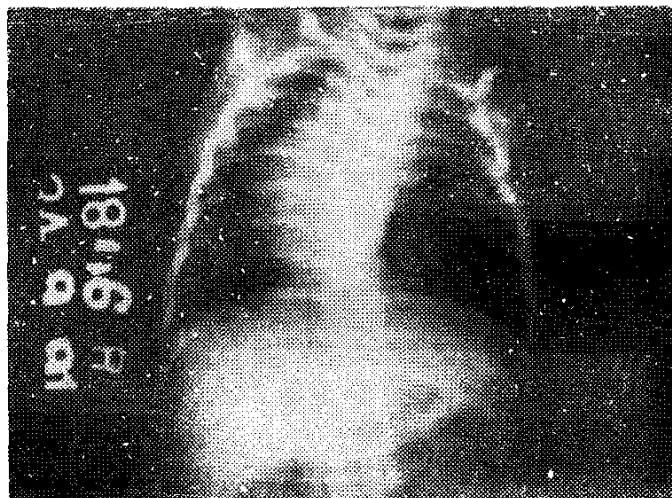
Radiograph showing Dextrocardia
